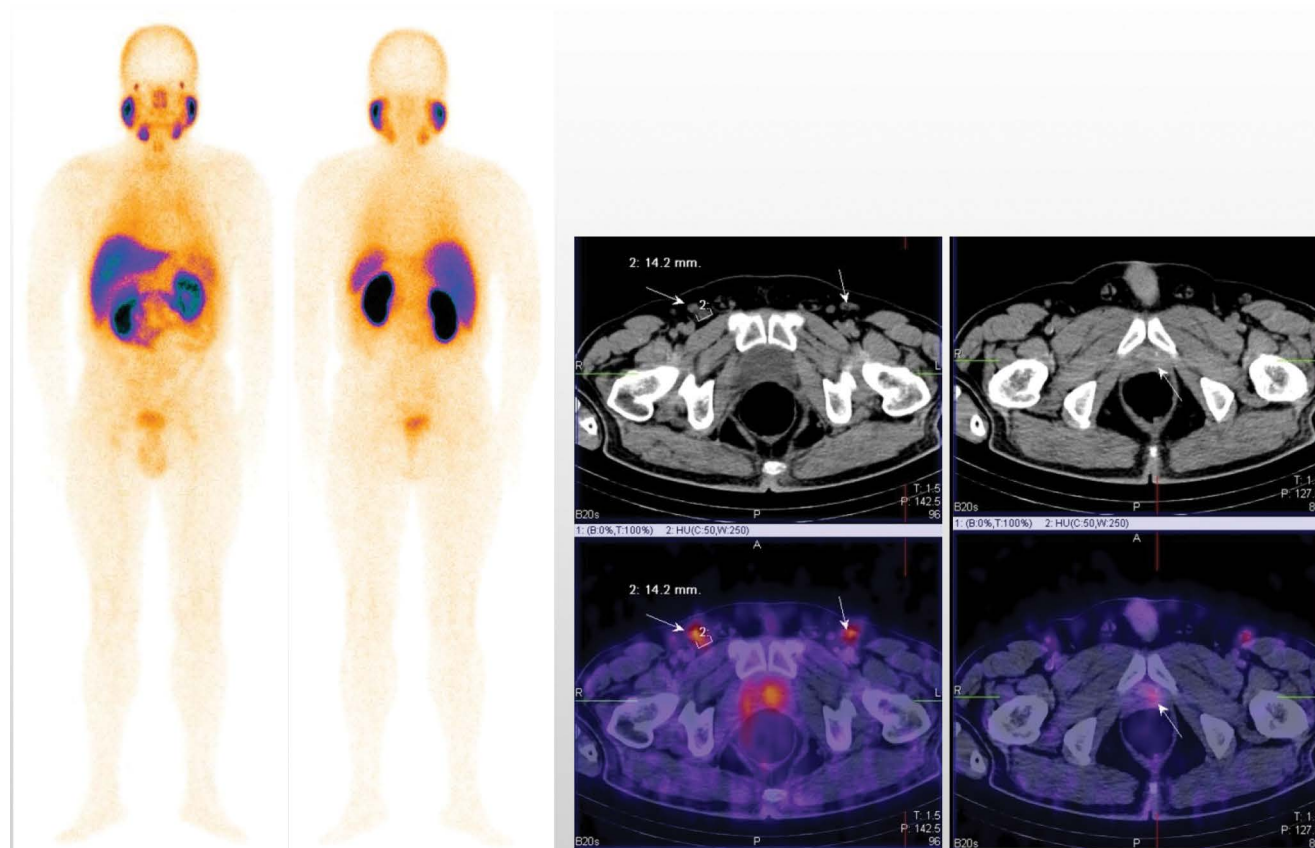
M/60yr with prostate cancer, pT2pN0M0, G2, Gl = 5 (3 + 2). Radical prostatectomy (2018). PSA = 0.5 ng/mL (01/2019). Whole-body scan and target ^{99m}Tc Tc-PSMA-T4 SPECT-CT imaging showed physiological tracer biodistribution in the liver, spleen, kidneys, lacrimal and salivary glands, oral and nasal mucosa, bowels and urinary bladder. Intensive ^{99m}Tc Tc-PSMA-T4 uptake was visualized in the prostatic bed suspicious for local recurrence, follow-up was required. There was moderate symmetrical activity in the inguinal bilateral lymph nodes, which were visualized with normal structure and size, with well-depicted lymphocytic sinus, interpreted as reactive lymph nodes
